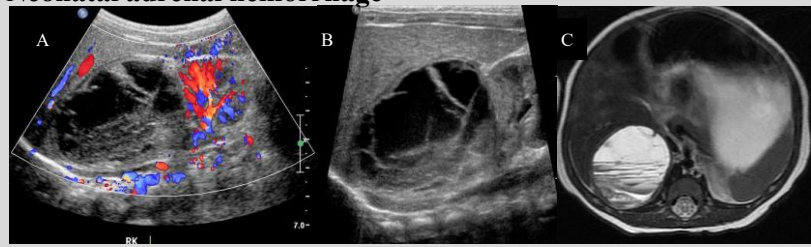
Fig A and B: A 3 week-old baby with a prenatal diagnosis of a cystic mass in the right upper quadrant. Post-natal ultrasound shows an avascular cystic mass with internal septations and debris, likely blood products.
